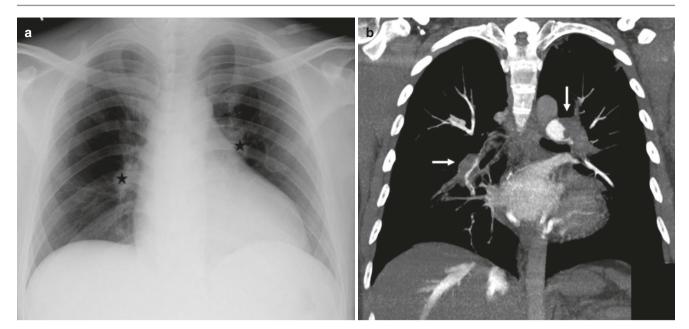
Pulmonary embolism. (a) AP chest radiograph shows bilateral upper and mid-zone oligemic regions with increased lung parenchymal lucency (Westermark sign) along with abrupt truncation
